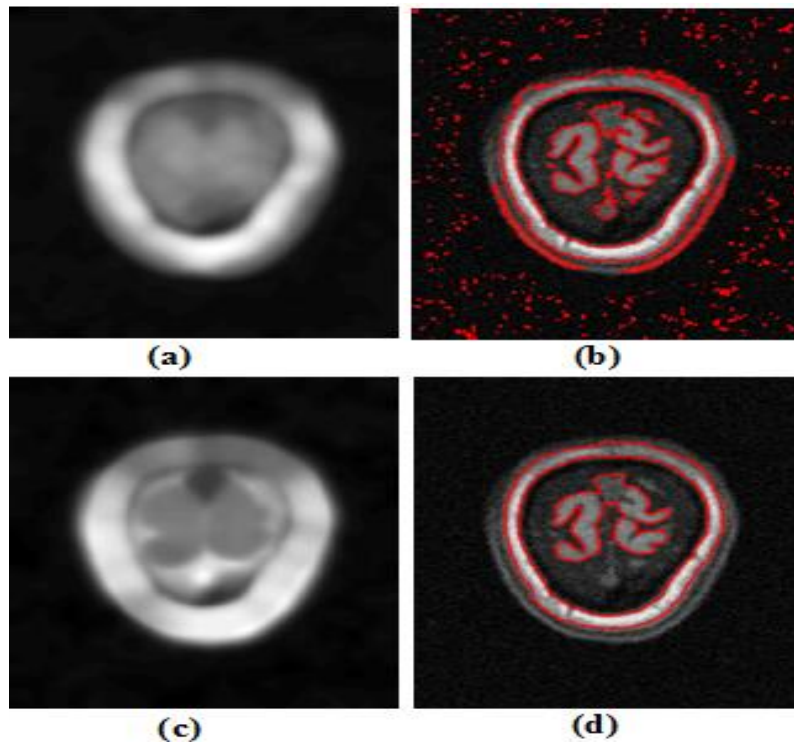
On a noisy MRI image (a, b) Bias field & final contour using B. N. Li et al method (c, d) Bias field & final contour using proposed method
